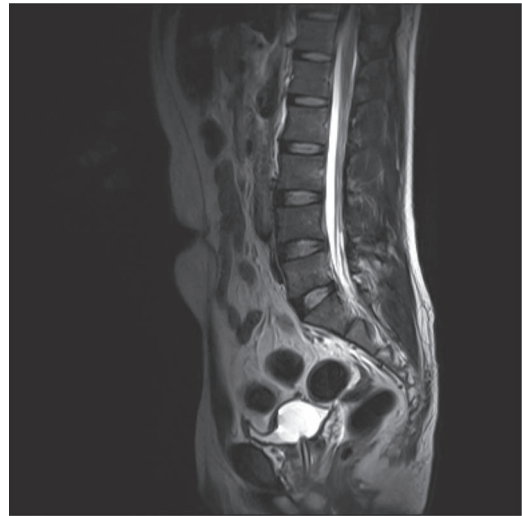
Unremarkable MRI of lumbar spine.
